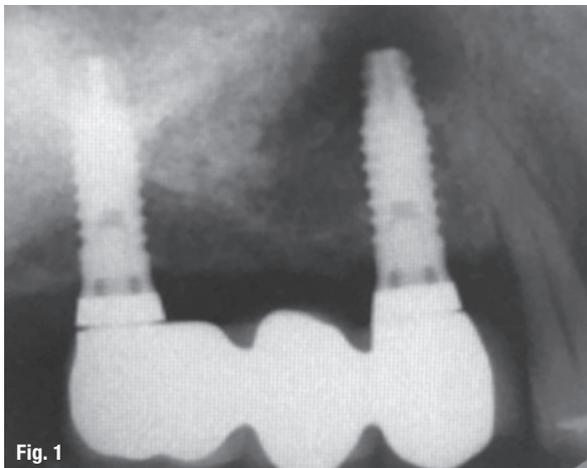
Pre-op radiograph: despite the large area of osteolysis, the implants did not show any signs of inflammation. Tooth #24 was vital.
